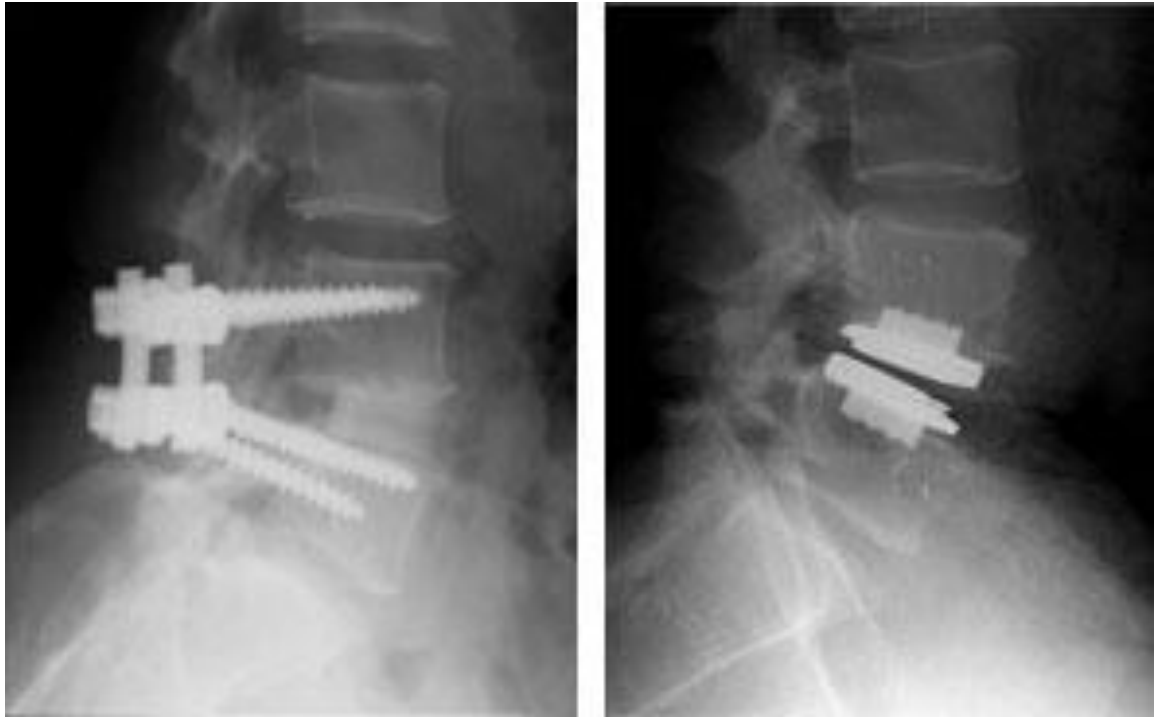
Computed tomography images showing implanted lumbar fusion rods (left) and ball on socket total disc replacement device (right) at the L4-L5 level (us.synthesprodisc.com).
